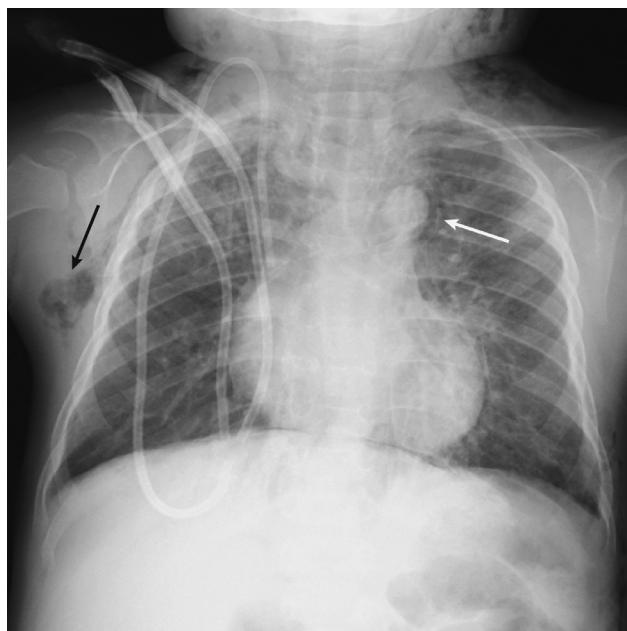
Chest radiography findings at admission of a 3-year-old boy with pneumorrhachis. Bilateral ground-glass opacities, subcutaneous emphysema (long arrow), and pneumomediastinum (white arrow) can be observed.
